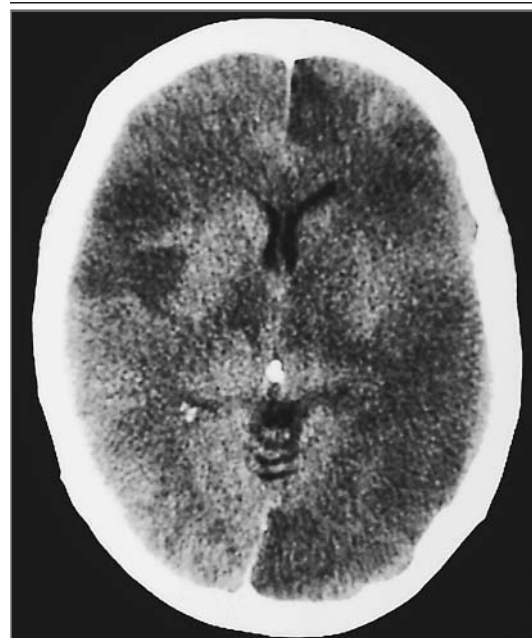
Computed Tomographic Scan of the Brain, Obtained Eight Hours after Cardiac Arrest, Showing Severe Edema and Infarction in the Anterior and Posterior Circulation of Both Hemispheres.
